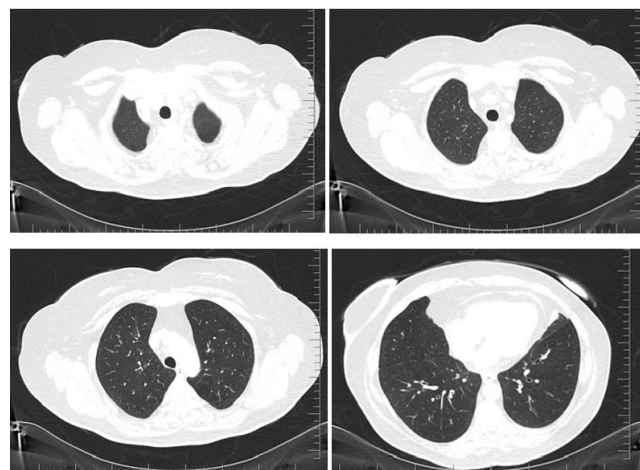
Follow-up HRCT: Complete resolution of prior ground-glass opacities. No signs of pneumonic infiltration or mass lesions. Minimal pericardial effusion persisted, and previously noted nonspecific nodules remained stable.
